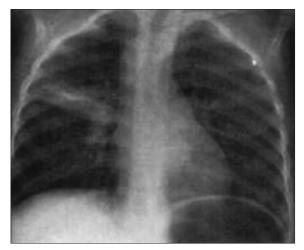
Chest posterior-anterior radiograph shows enlargement of right hilar nodes, paratracheal and left hilar lymphadenopathy right upper lobe opacities
